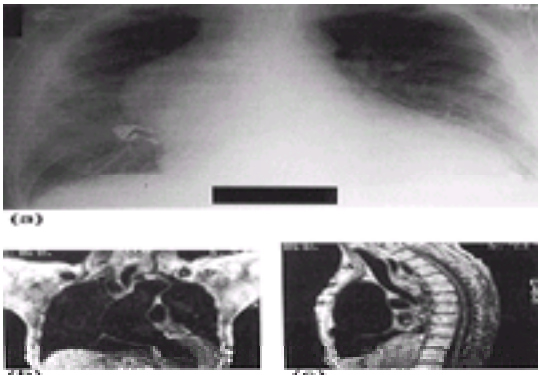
Aortoannular ectasia: (a) plain chest radiograph showing a large ascending aortic aneurysm; (b) MRI scan showing an ascending aortic aneurysm extending into the arch;(c) nuclear magnetic resonance scan, lateral view.
